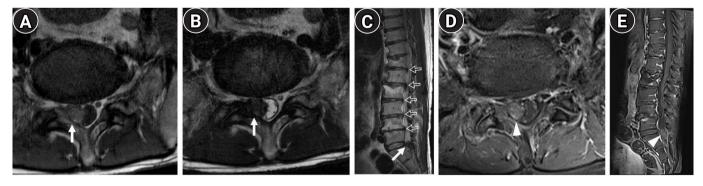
Preoperative lumbar magnetic resonance images. Axial T1-weighted (A) and T2-weighted (B), and sagittal T2-weighted (C) images show an irregular mass lesion (closed arrows) involving the right facet joint at L5–S1 and the right epidural space at the L5–S1 level. Multiple bulging discs (open arrows) with compression fractures in the T12 and L2 vertebral bodies are also shown on sagittal T2-weighted images (C). Heterogeneous enhancement of the mass is shown on gadolinium-enhanced T1-weighted axial (D) and sagittal images (E) (arrowheads).
